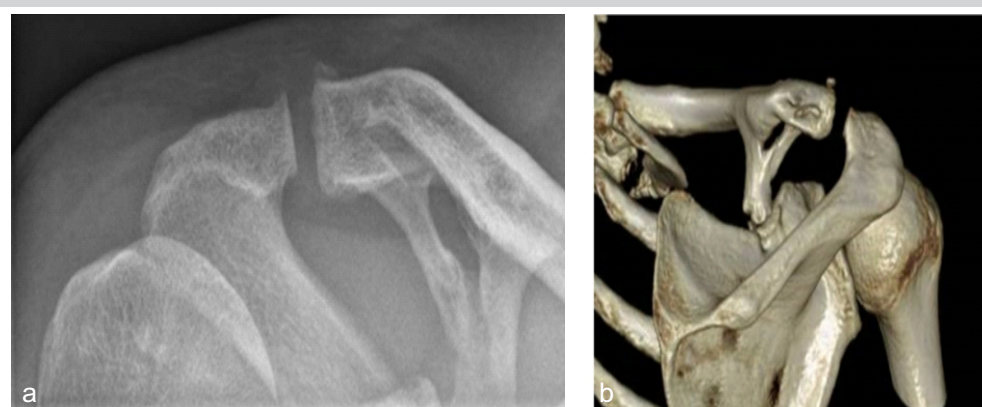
(a and b) Anterior-posterior view X-ray of the right shoulder and posterior view of 3D reconstruction computed tomography scan of case 1.
